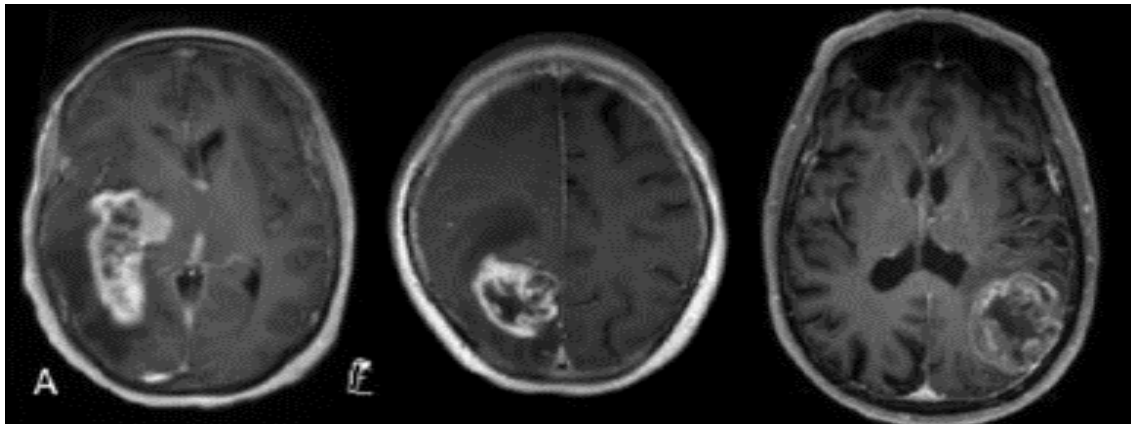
Different examples of glioblastoma appearance using Conventional brain MRI with contrast.*
